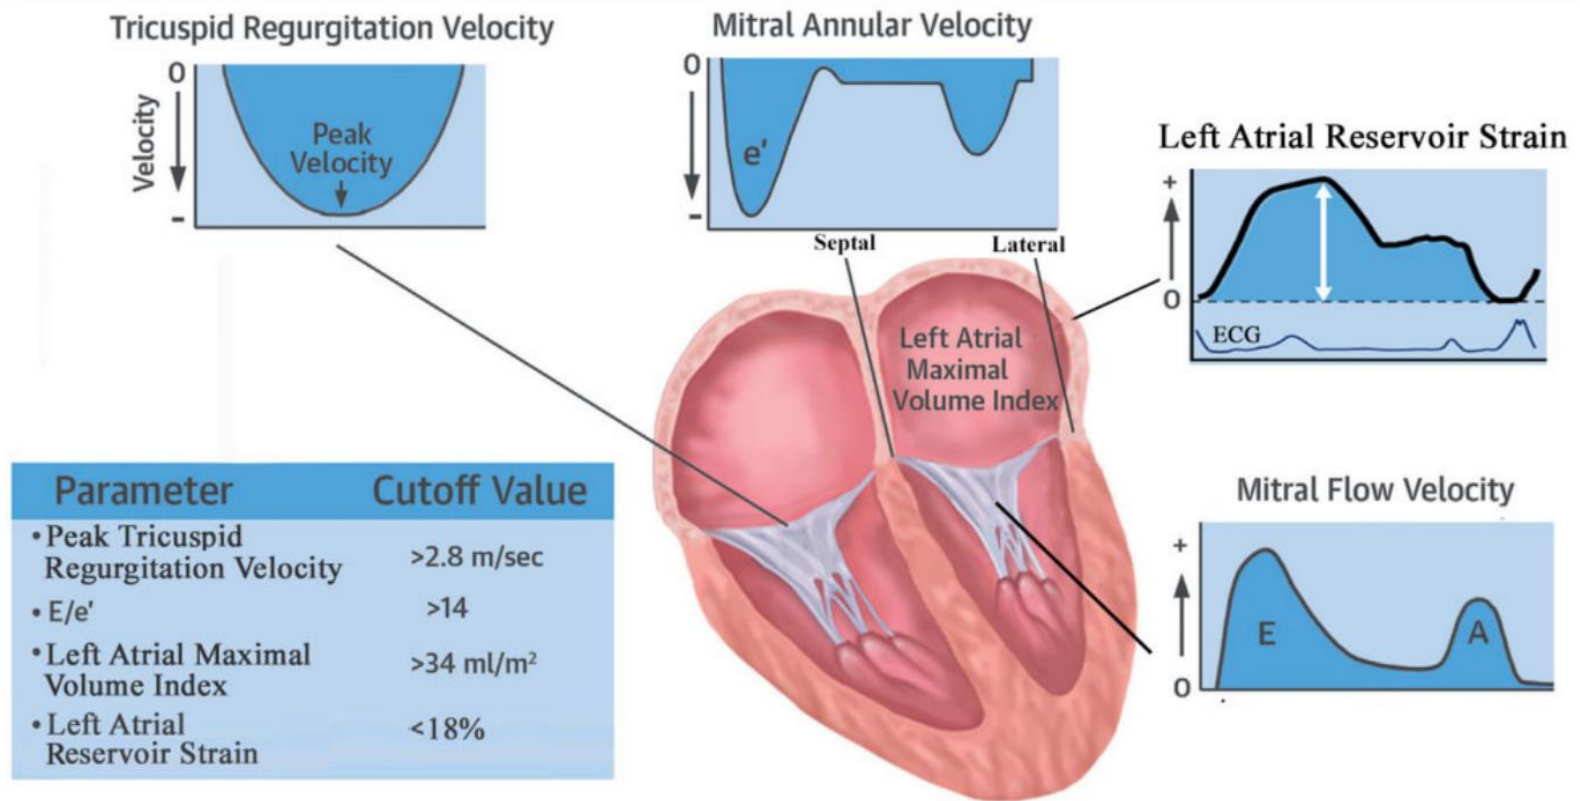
Echocardiographic parameters for evaluation of LV filling pressure.
